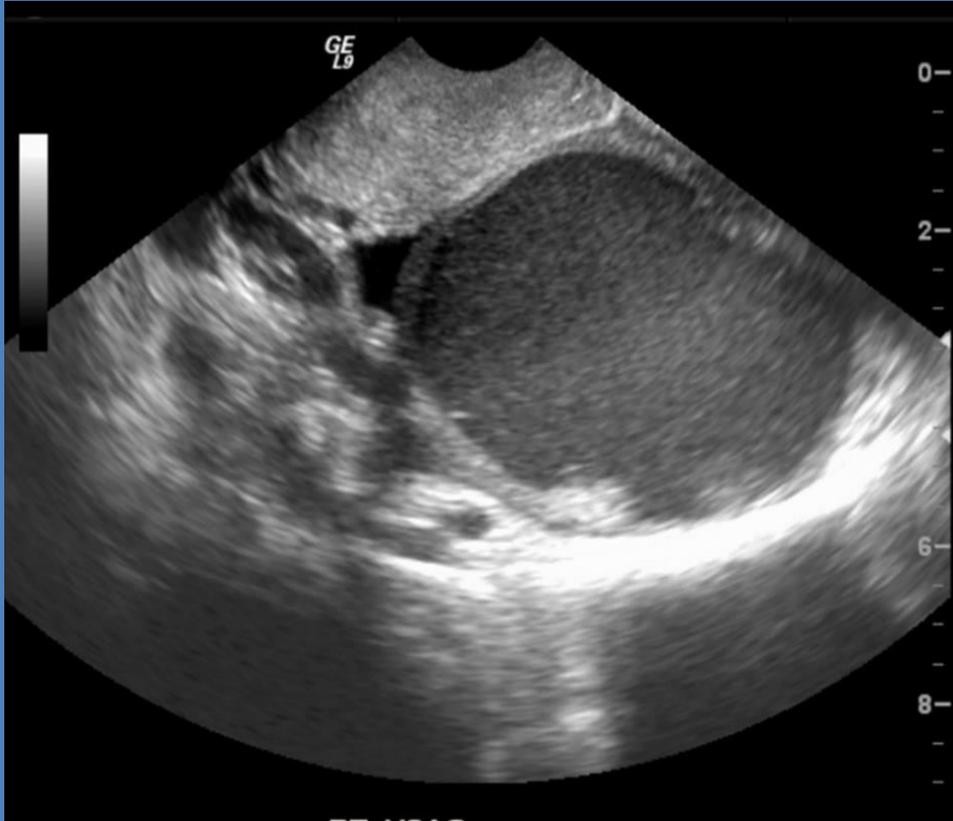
Endometrioid borderline tumor that developed in an endometrioid cyst in a 30-year-old patient. The ovarian lesion appeared as a unilocular-solid lesion (largest diameter of mass, 46 mm) with a papillary projection (height = 29 mm) (a), which was highly vascularized at power Doppler examination (b).
